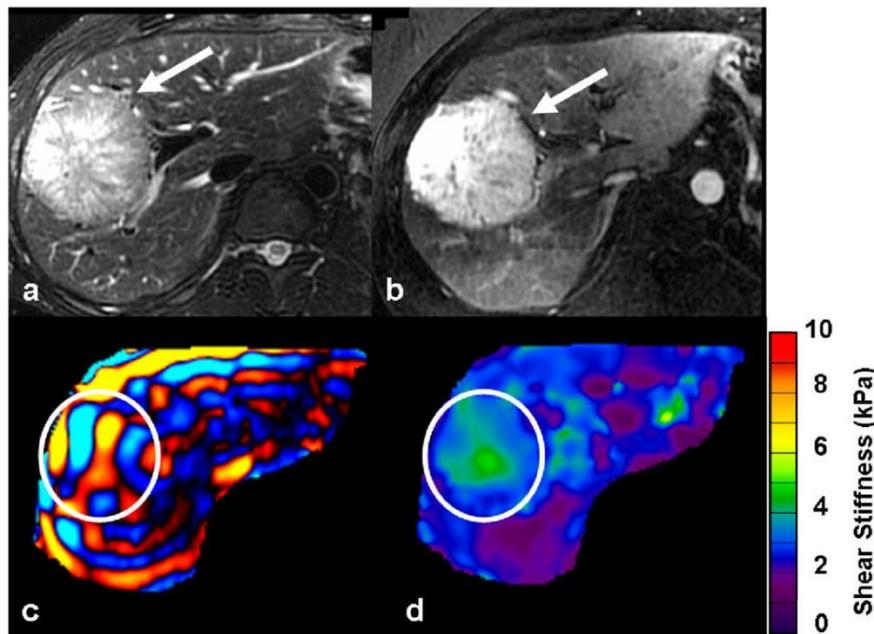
39-year-old man with incidental liver tumor. A large tumor in the right lobe of the liver was incidentally detected during an ultrasound examination. The tumor (*white arrow*) is hyperintense on the T2-weighted image (a) and seen to intensely enhance in arterial phase of gadolinium enhanced T1-weighted image (b). Axial MRE wave image (c) showing good illumination of the tumor (ROI). Note that the waves in the tumor have slightly longer wavelength as compared to those in surrounding normal liver parenchyma. Elastogram (d) with ROI corresponding to the tumor. The shear stiffness value of the tumor was 3.1kPa and the surrounding liver, 2.4kPa. Patient underwent right hepatectomy and final diagnosis was hepatic adenoma [46].
